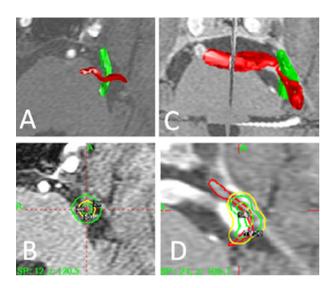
Axial MR images showing small vessel compression of trigeminal nerve (A) and target localization of the entry zone of the trigeminal nerve with the 20% isodose line at the brainstem margin (B). A large blood vessel (vertebral or basilar artery) compressed the trigeminal nerve (C) and multiple 4-mm shots to cover the elongated trigeminal nerve (D).
